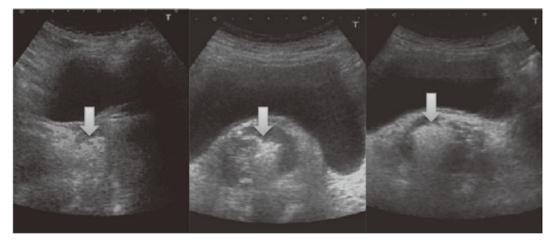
Ultrasound-guided injection of the agent KORTUC II through a spinal needle (22 gauge, 9 cm) into the tumor. Hyperechoic area spread was induced by the generated oxygen (arrows).
